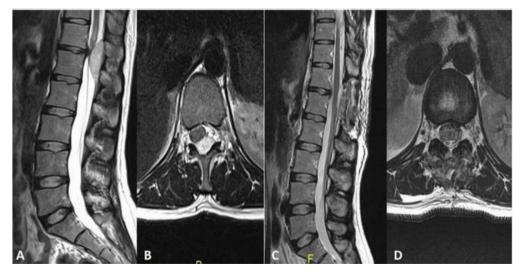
Prepareative thoracolombar MRI showed an extradural mass (a and b), early postoperative MRI (c) sagittal and (d) axial sections.
